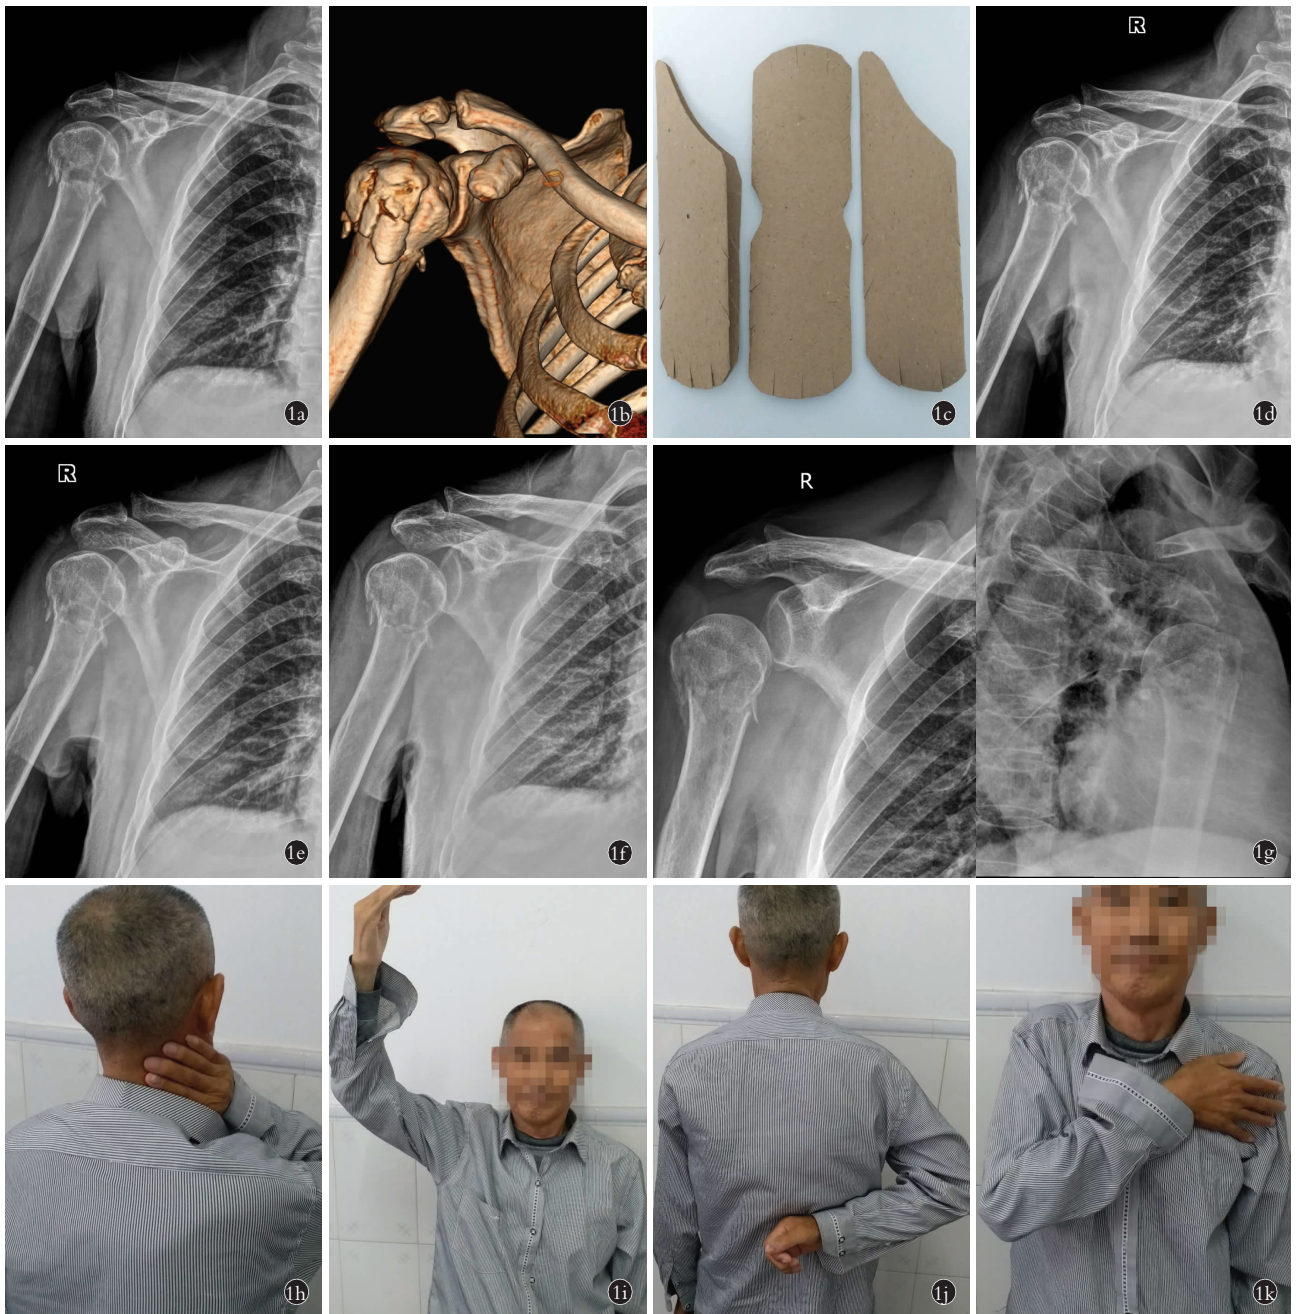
患者,男,69 岁,外伤致右肱骨近端粉碎性骨折(3 部分骨折) 1a. 治疗前右肩关节正位 X 线片示骨折断端粉碎,远近端分离移位 1b. 治疗前右肩关节 CT 三维重建示骨折断端多片碎骨块,大结节部分分离,远近端稍有分离移位 1c. 患者体形偏瘦,肩部肌肉单薄,根据其外部特征剪裁的可塑纸板宽度可稍窄 1d. 手法复位 1 d 后右肩关节正位 X 线片示远近端局部分离移位 1e. 手法复位后 1 周右肩关节正位 X 线片示骨折端有嵌插,断端稳定且位置较前改善 1f. 手法复位后 2 周右肩关节正位 X 线片示骨折远近端及大结节碎骨块稳定,位置尚可 1g. 手法复位后 4 周右肩关节正侧位 X 线片示骨折断端位置满意,局部骨痂生长 1h, 1i, 1j, 1k. 手法复位后 12 周外观患肢手可触及后颈部,患肢手可至背部 T₁₂ 椎体处及健侧肩部
